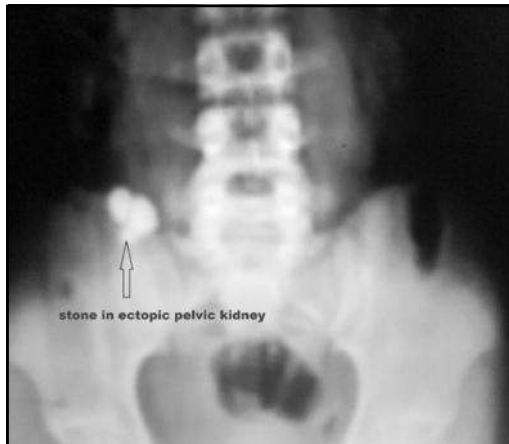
plain X-Ray KUB- showing renal stone in ectopic pelvic kidney (1)
